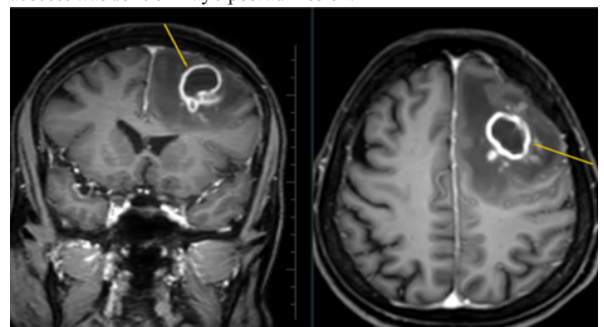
MRI Brain showing Ring enhancing lesion in left frontal region with moderate to severe surrounding edema
